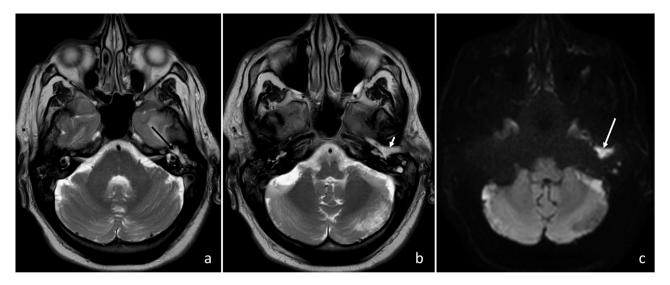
Axial MRI of the brain. T2 weighted image at the level of the mastoid temporal bone (a) shows fluid in the left mastoid air cells (black arrow) which is seen in the setting of mastoiditis. T2-weighted image at the level of the middle ear (b) and diffusion weighted image at the same level (c) show fluid/debris in the left middle and external auditory canal (short white arrow) with corresponding restricted diffusion compatible with the surgically proven cholesteatoma.
